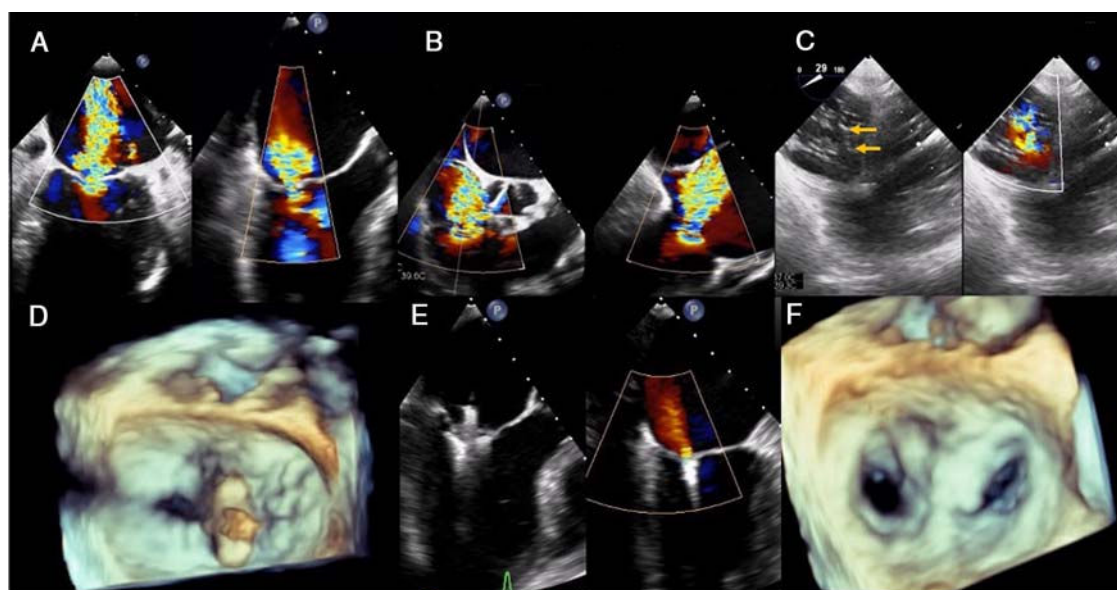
A: TEE showing severe mitral regurgitation. B: TEE mid-esophageal view of the torrential tricuspid regurgitation. C: TEE showing gaps along the line between the anteroseptal and posteroseptal commissures (arrows). D: 3D TEE showing clip at the mitral valve. E: TEE of insertion of leaflets in the clip and result. F: 3D TEE of the mitral clip final result. TEE: transesophageal echocardiography.
